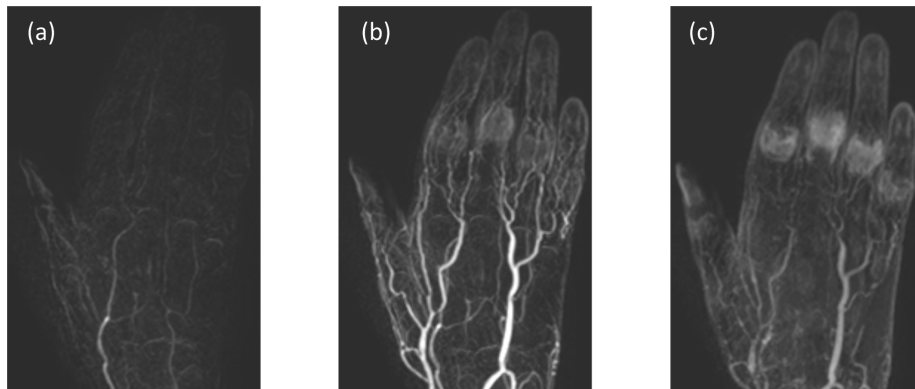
Sequence of DCE-MR images for RA diagnosis. (a) Coronal MIP at time of first Gd agent flooding. (b) Corresponding MIP at peak intensity time. (c) After the signals in the large vasculature have decayed, strong signals are observed from the inflamed joints.
